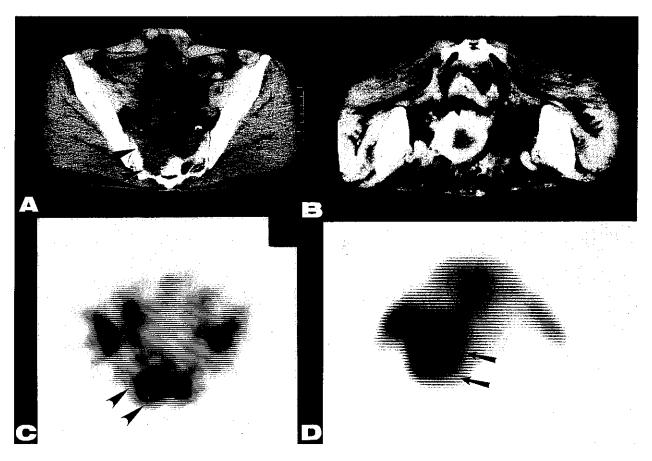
CT scans (A, B) and SPECT images of patients #4 (C) and #6 (D) with recurrent rectal cancer in the pelvic lesion. Recurrent tumors (indicated by the arrows) were clearly visualized by the CEA102 scintigraphy.
